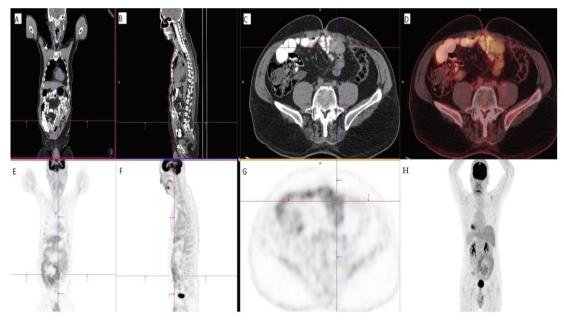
In patients with malignancy with a history of surgery, internal hernia should be considered in the differential diagnosis of lesions with suspected malignancy. Before making treatment decisions, the contribution of oncologic ¹⁸F-fluorodeoxyglucose (FDG) positron emission tomography (PET)/CT imaging, which reflects the metabolic status of suspicious lesions, is crucial (5,6). Findings that are not associated with malignancy but are detected incidentally on PET/CT scanning are becoming more common (7). Coronal (A)-sagittal (B) and axial (C) sections of CT images, axial section of fusion image (D), coronal (E)-sagittal (F) and axial (G) sections of PET images, and maximum intensity projection (H) image of PET/CT scan was performed patient with a suspicious implant lesion on the anterior abdominal wall. ¹⁸F-FDG PET/CT scan showed that the suspicious lesion, which seen on abdominal CT disappeared. It was observed that there was an oral contrast material passage in the existing intestinal loops in this region, and there was no pathological ¹⁸F-FDG uptake compatible with the implant on the anterior abdominal wall. Thus, thanks to PET/CT imaging, we excluded the diagnosis of implant and recurrent disease in our patient. When CT images of the abdomen were re-evaluated together with PET/CT images, it was seen that the suspicious lesion was observed as a sac on diagnostic CT, and it was compressing the small intestines in this state. Additionally, the convergence of adjacent mesenteric fatty planes and vascular structures into the sac was detected as supporting internal herniation. In a patient with rectal cancer with a history of LAR and radiotherapy, it was concluded that the image that was first evaluated as an implant on CT was internal herniation that was spontaneously reduced by ¹⁸F-FDG PET/CT scanning.
